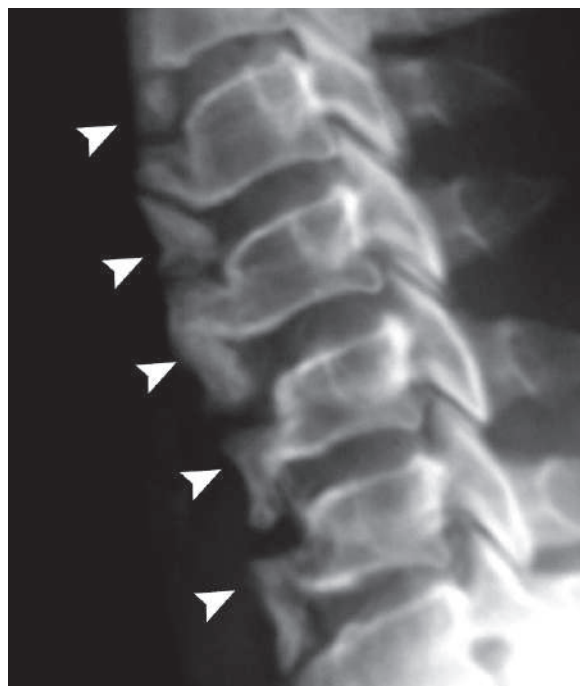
Lateral plain radiograph of the cervical vertebrae shows multisegmental vertebral fusion due to ligamentous calcification and ossification due to diffuse idiopathic skeletal hyperostosis (DISH) (*arrowheads*)
